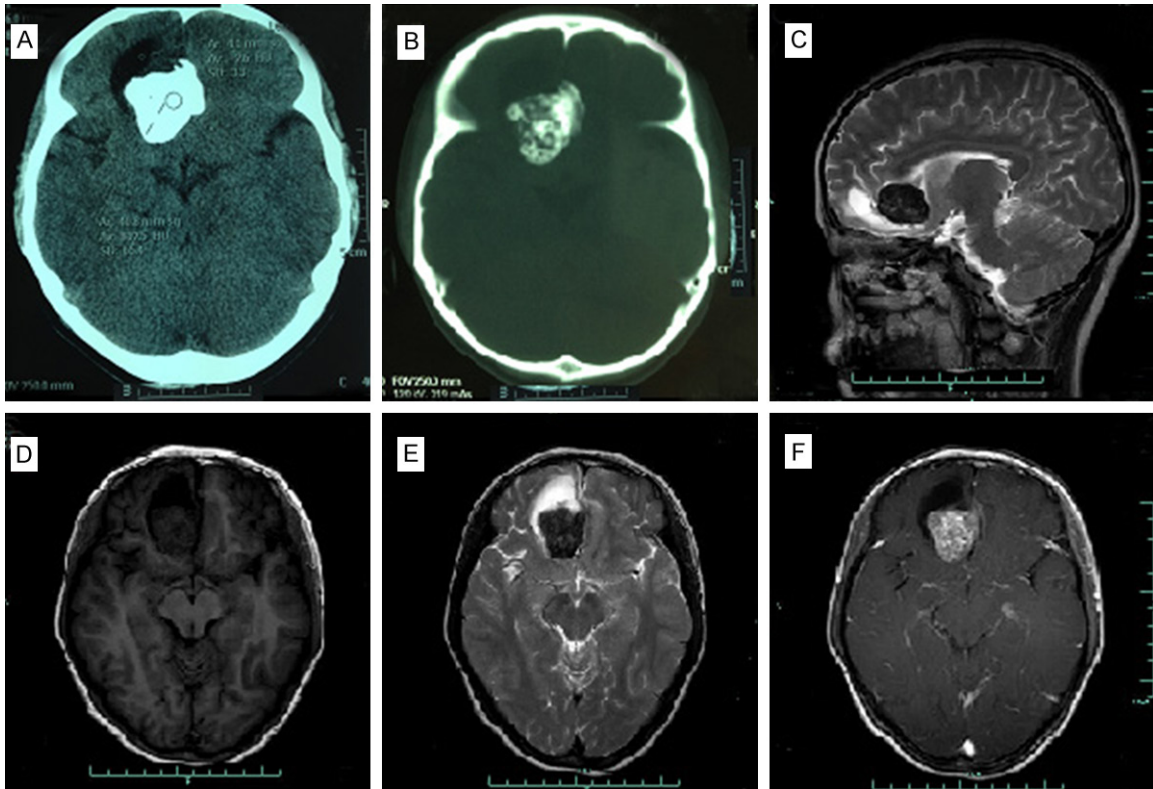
Cranial CT and MRI. Axial CT (A) demonstrates a homogeneous high-density lesion in the frontal lobe when set to bone window (B). Sagittal T2 (C), axial T1 (D), T2 (E) and postcontrast T1 (F) MRI demonstrate a heterogeneous lesion in the frontal lobe, anterior inferior of which was a cystic lesion.
